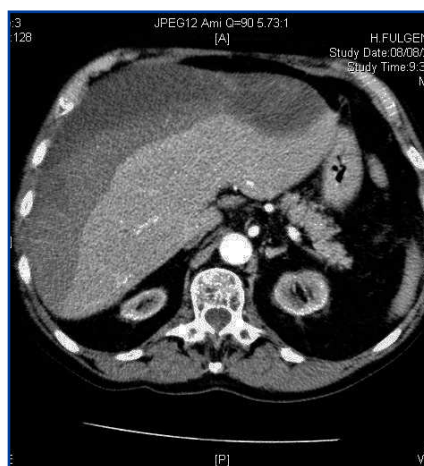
Contrast CT of the abdominal area. Subcapsular hepatic haematoma measuring 10 x 7 x 20cm at the level of the right lobe. Atrophic kidneys.
